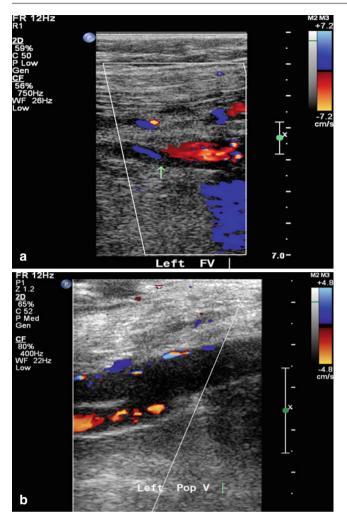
Duplex ultrasound showing chronic DVT of femoral vein with both B-mode (*arrow*) (a) and colored duplex (b)
